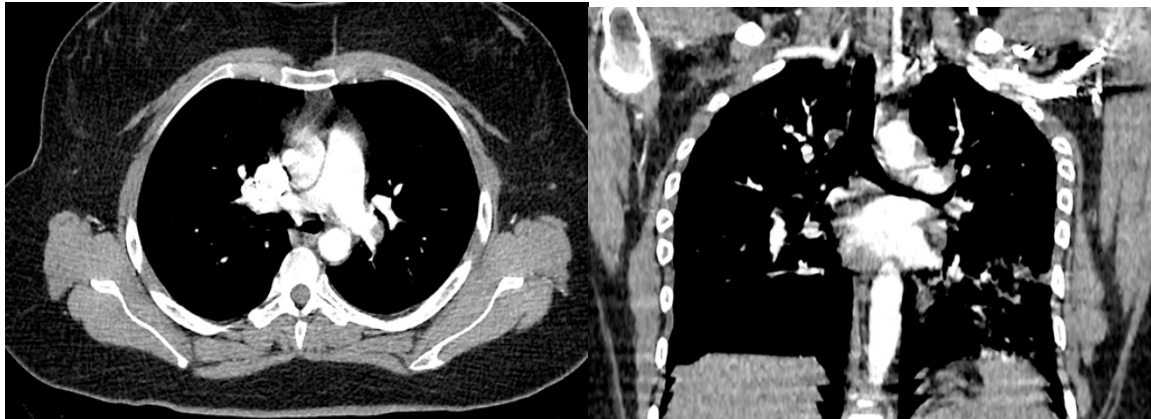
(A & B) A case of 35yr old female with moderate COVID-19 pneumonia, admitted to the ICU. Image showing CT-PA axial and coronal sections depicting a thrombus (red arrow) at the left main pulmonary artery - lobar type.
